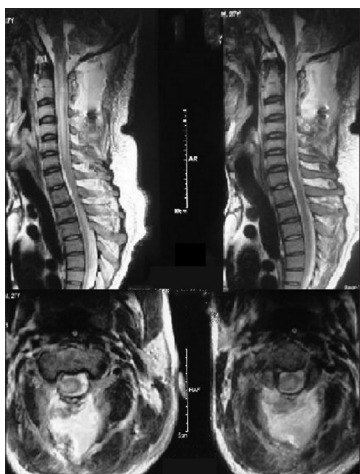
Post operative MRI showing cord signals from cervico-medullary junction to C6 vertebral level. Axial images showing the C2 laminectomy defect and preserved cord substance at the affected level
